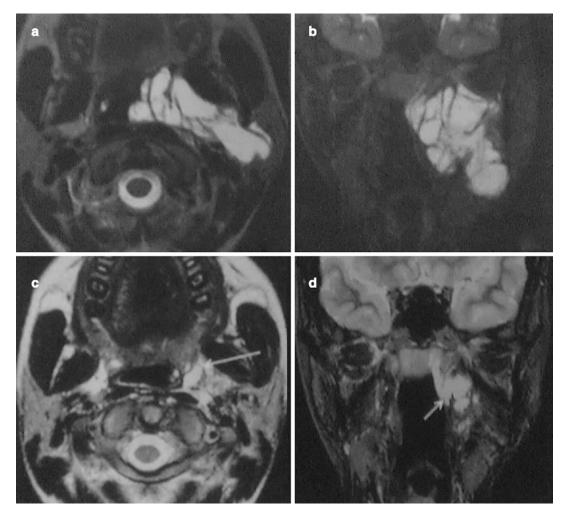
A 16-year-old female present with a leftsided neck swelling extending up to the parapharyngeal space. (a) Preoperative Magnetic resonance imaging axial section showing a hyperintense lobulated venolymphatic malformation involving the parotid and the parapharyngeal space. (b) Preoperative Magnetic Resonance imaging sagittal section showing hyperintense lobular lymphatic
